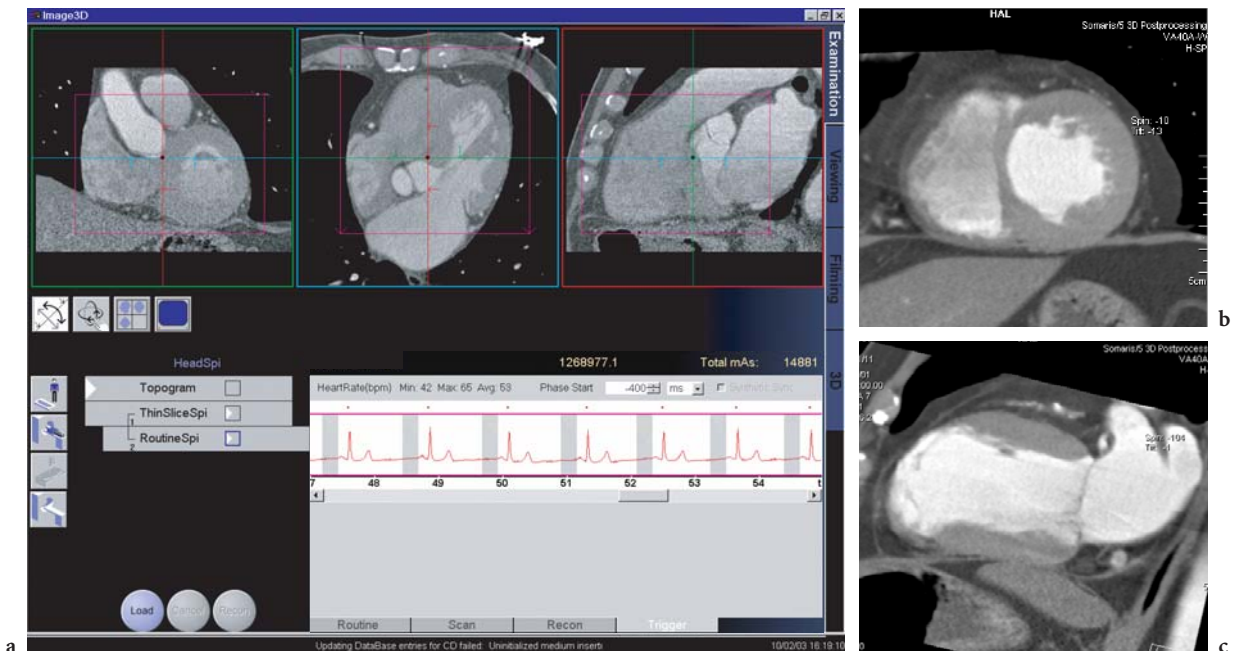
Direct MPR reconstruction for a cardiac CT examination obtained on a 16-slice CT scanner. True 3D-based planning of the MPR views (a) enables direct reconstruction of MPR stacks from the scan data with pre-defined MPR thickness and increment. The usual step of generating axial slices can be skipped. In the example given, MPR stacks in short (b) and long heart (c) axes are generated in diastolic phase. (Case courtesy of Tübingen University, Germany)
